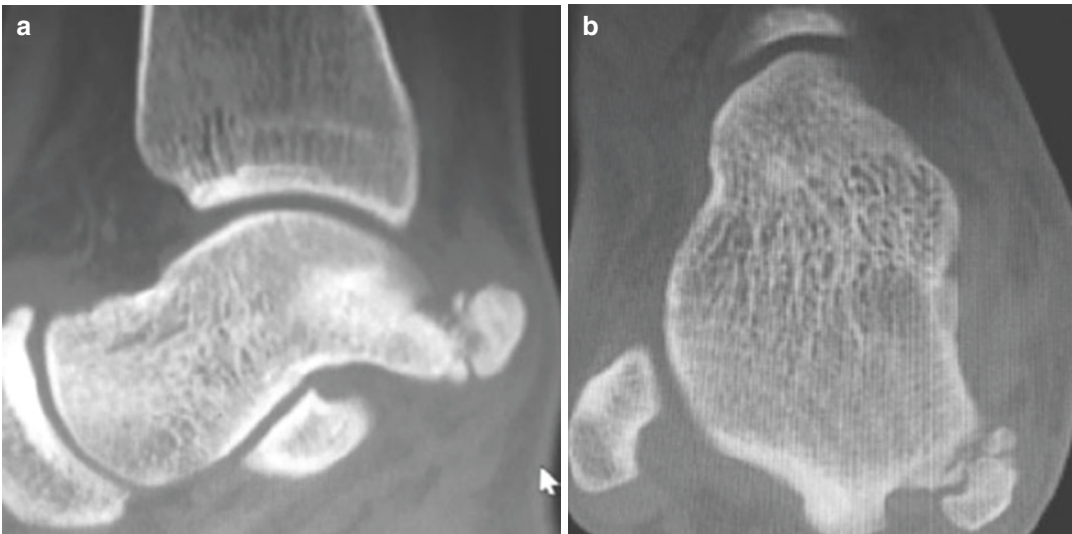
(a) Sagittal CT image of a Cedell fracture in an athlete's ankle. (b) Axial CT image of a Cedell fracture in an athlete's ankle (image copyright: Pieter D'Hooghe)
